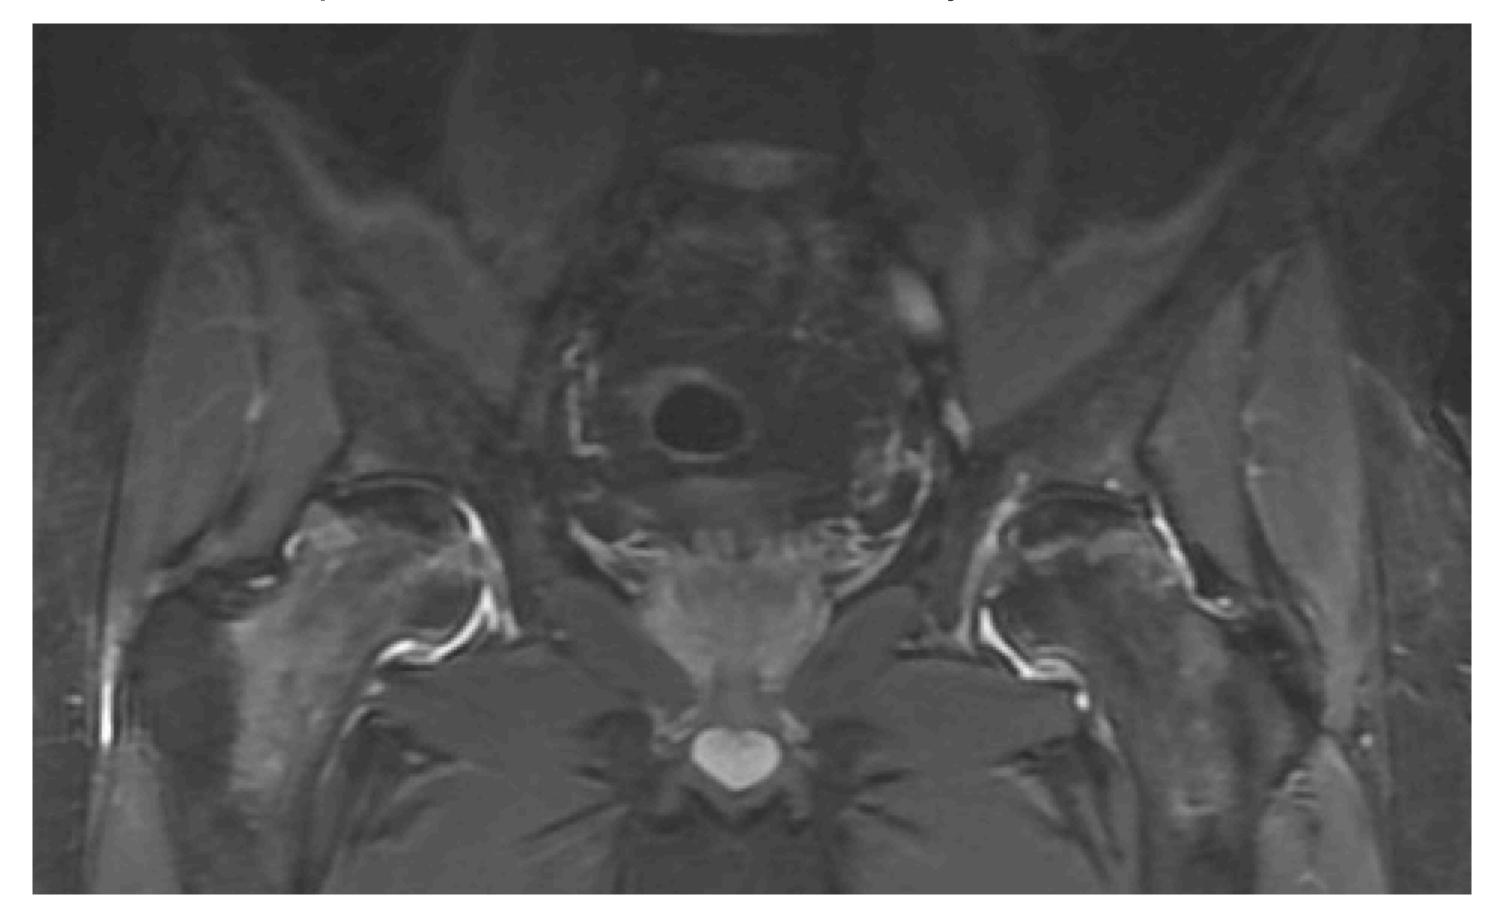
Coronal STIR MRI of the bilateral hips revealing osteonecrosis of the bilateral femoral heads with minimal flattening of the right femoral head but without subchondral collapse
